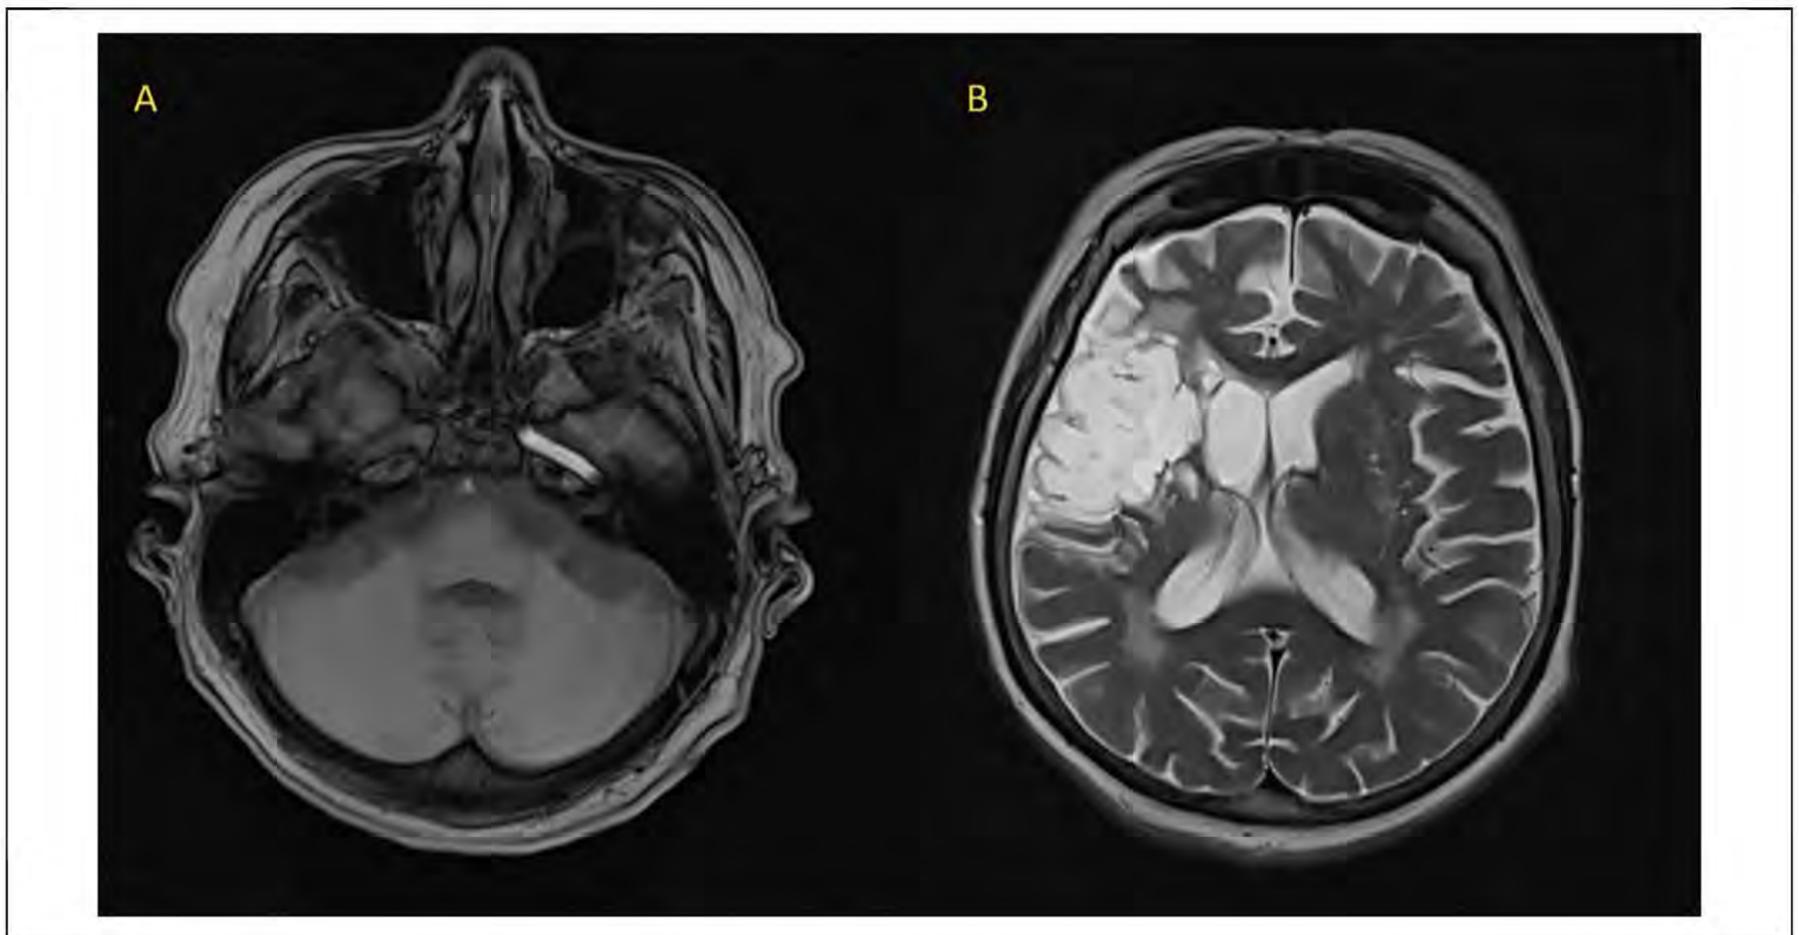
Depicts pretreatment images of MRI. (A) The 3D time of flight MRA image. (B) T2-weighted axial image. Abbreviations: 3D, three-dimensional; MRI, magnetic resonance imaging.
